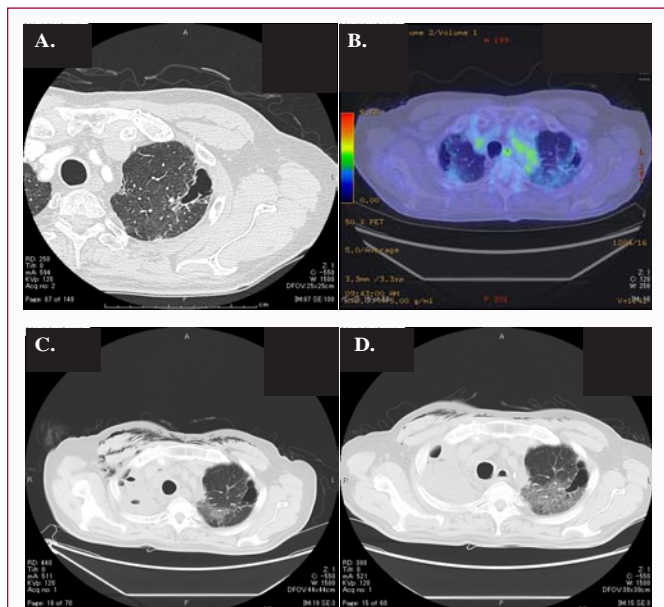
Representative image of a postoperative AE case. Right upper lobectomy was performed for lung cancer. No ground glass changes were seen on preoperative HRCT (A), but an FDG uptake was seen in the left upper lobe on preoperative PET (B). Postoperative AE of UIP occurred at postoperative day 10. Ground glass changes in the left upper lobe were seen on CT at postoperative day 10 (C), with gradual enhancement noted at postoperative day 14 (D).
